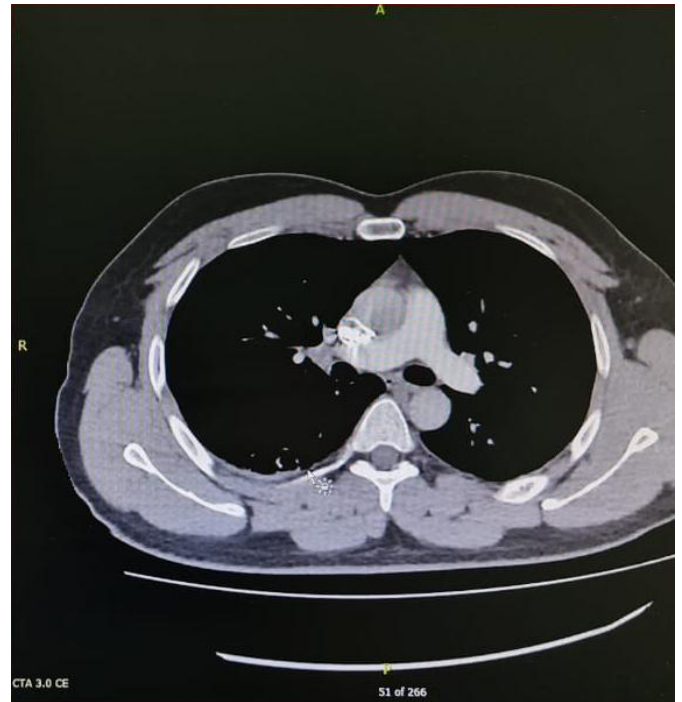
CT Angiography showing no evidence of pulmonary embolism.
